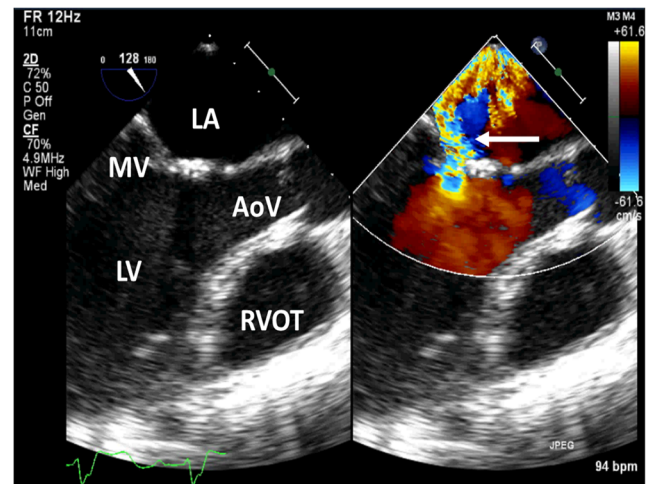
2-D transesophageal echocardiography, three-chamber midesophageal view of a 36-year-old female with a history of Hodgkin's lymphoma at the age of 18 with a history of mediastinal radiation therapy and chemotherapy presenting with dyspnea. Findings are consistent with radiation-induced valvulopathy with combined mitral valve regurgitation and stenosis. The mitral valve appears thickened with restrictive leaflet motion. On the *right panel*, color Doppler across the mitral valve demonstrates severe mitral regurgitation is noted (*arrow*), along with mitral stenosis with a mitral valve area of 1.4 cm². LA left atrium, LV left ventricle, MV mitral valve, AoV aortic valve, RVOT right ventricular outflow tract
